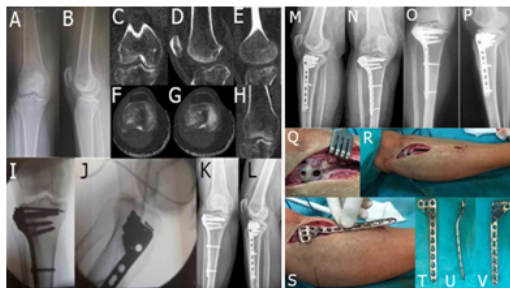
(A-V) Fracture of the lateral tibial plateau type II Schatzker. Plate and bone substitute. (A, B) preoperative X-rays; (C-H) CT exam; (I, J) intraoperative fluoroscopic image with excellent reduction of the articular surface, filling the bone defect with Atlantik® bone substitute, osteosynthesis with 2 Kirschner wires and a locked plate; (K, L) X-ray control at 1 month; (M, N) X-ray control at 3 months (radiologic evidence of decreasing granular aspect of bone substitute); (O, P) X-ray control at 12 months; (Q) intraoperative aspect after plate removal with cortical window and osseointegration of the bone substitute; (R, S) wounds aspect after plate removal with MIPO incisions and plate position; (T-V) aspect and design of a LCP-PLT plate with limited contact.
